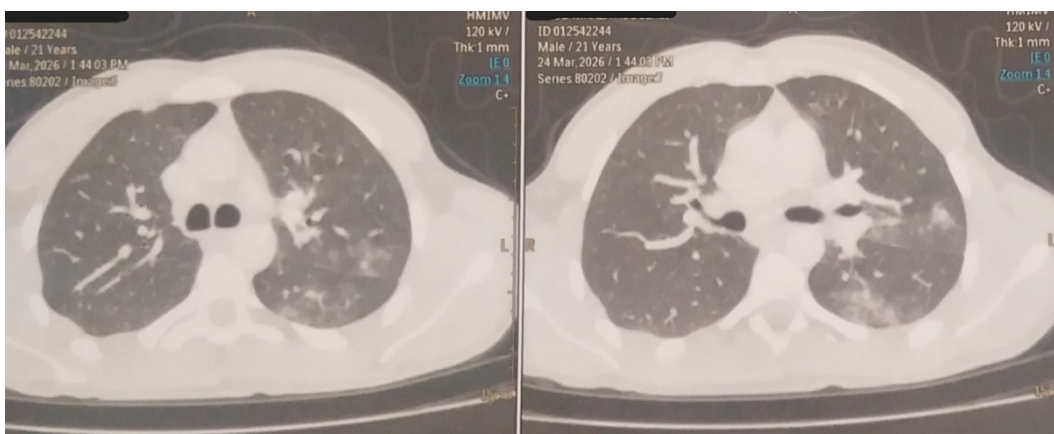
Chest CT scan in parenchymal window, showing ground-glass nodules in the left upper lobe and left Fowler.
